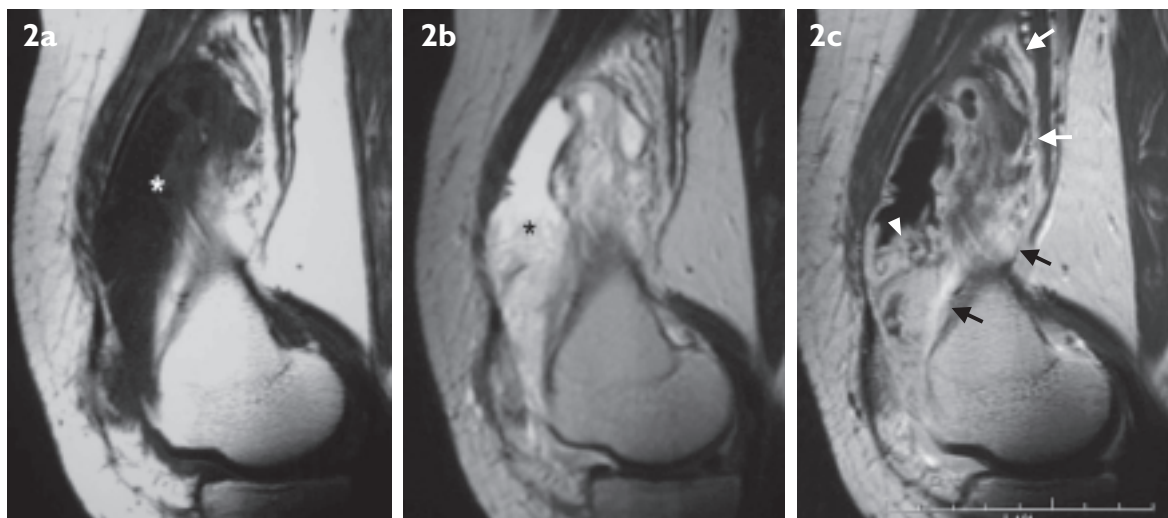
Suprapatellar bursitis. Sagittal (a) T1-weighted and (b) T2-weighted MR images show a grossly enlarged suprapatellar bursa (asterisk) containing a moderate amount of fluid. (c) Enhanced sagittal T1-weighted MR image shows a thick enhancing wall (arrows) with numerous villous protrusions (arrowhead).
